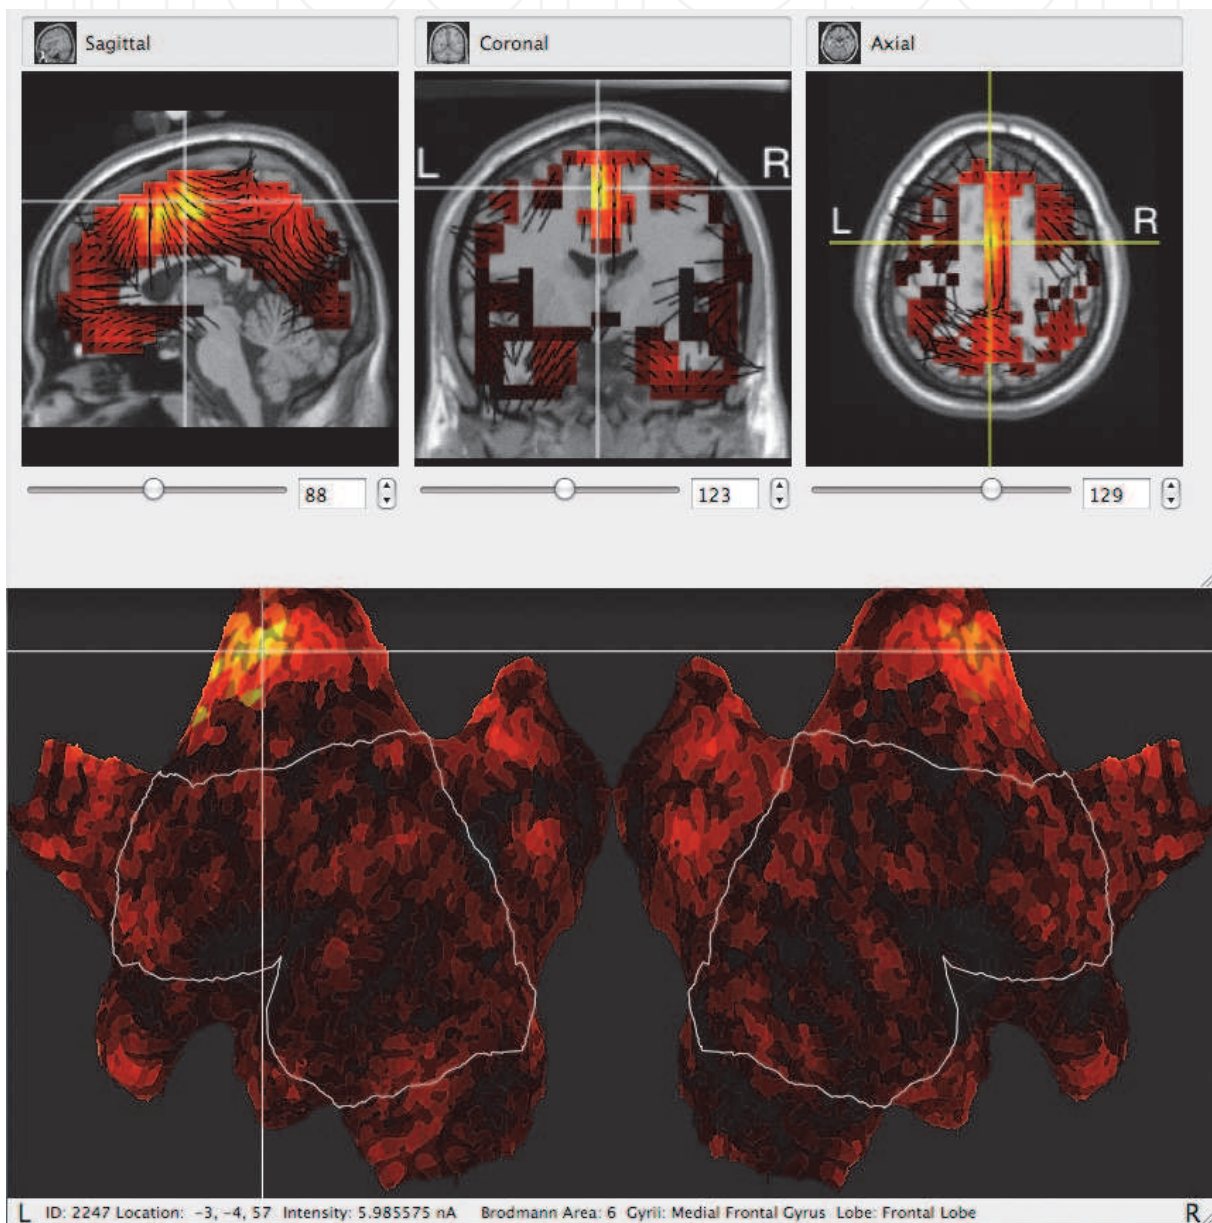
Source analysis of onset of discharges in Fig. 4 (top) suggest localization of onset in medial frontal cortex. The flatmap (bottom) shows the flattened cortical surface of the standard MRI model used in source analysis, with regions of maximal intensity denoted by crosshairs.
